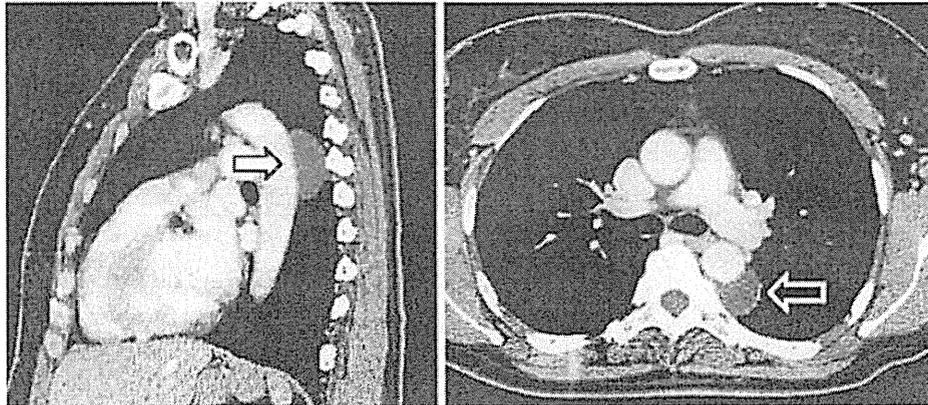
Enhanced chest CT showing a unilocular, unenhanced cystic mass, 4 cm in diameter, behind Th4, 5, and the descending aorta (arrow).
